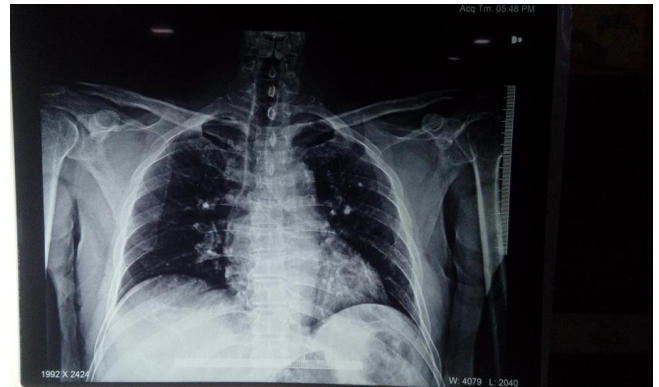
Radiographs of both shoulders showing Sub-coracoid fracture dislocation on left side with Sub-glenoid type dislocation on right side.
